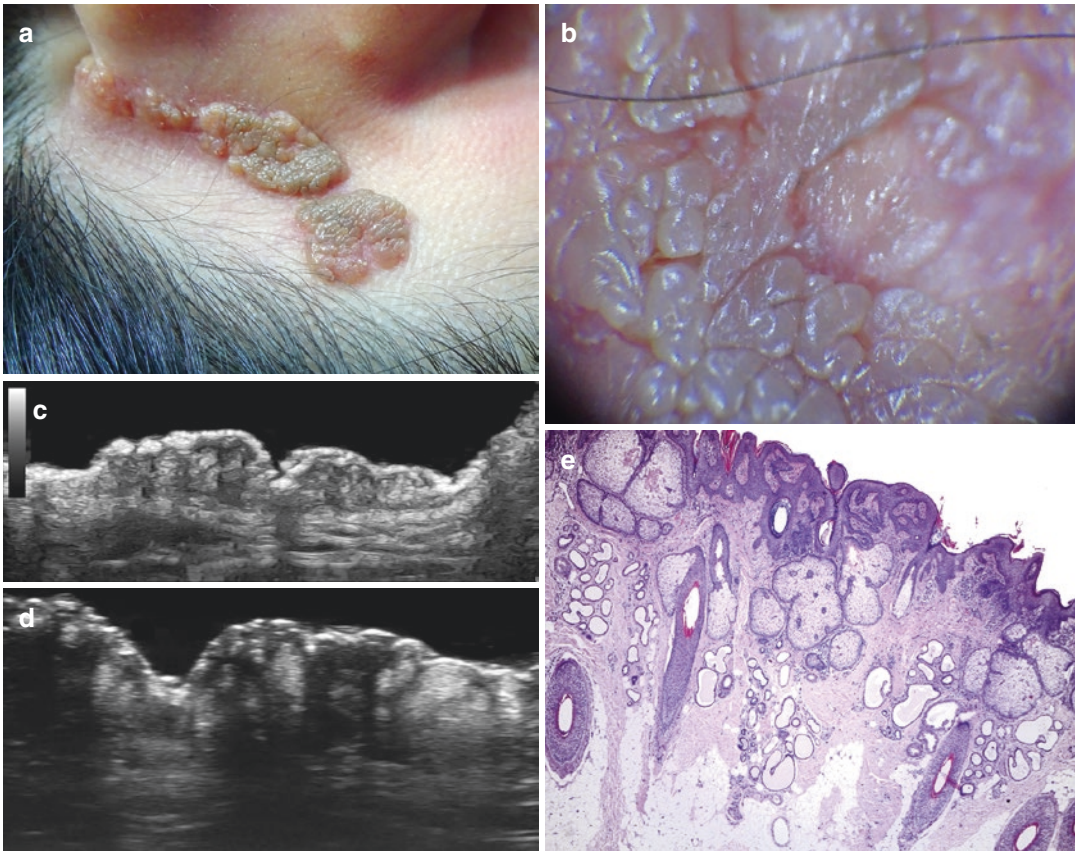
Nevus sebaceous of Jadassohn. (a) Clinical image. (b) Dermoscopy image. Grayscale ultrasounds (c at 24 MHz; d at 70 MHz transverse view; right retroauricular region) show heterogenous dermal plaque that displaces upward the epidermis. Notice the hyperechoic
